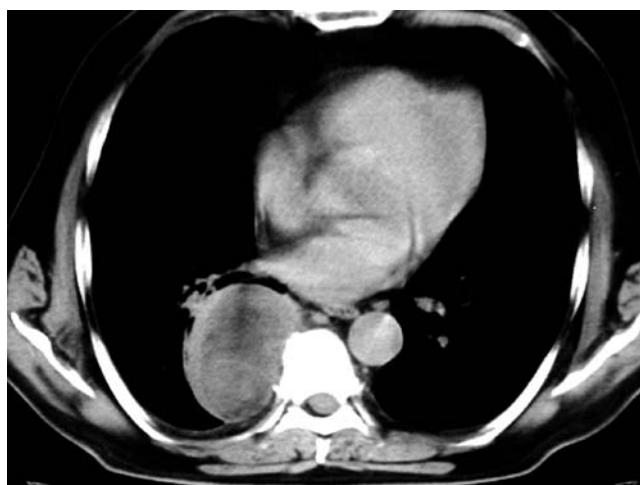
Liposarcoma. CT image showing heterogenous right tumor mass with areas of attenuation (Reproduced with permission from Radiographics).
